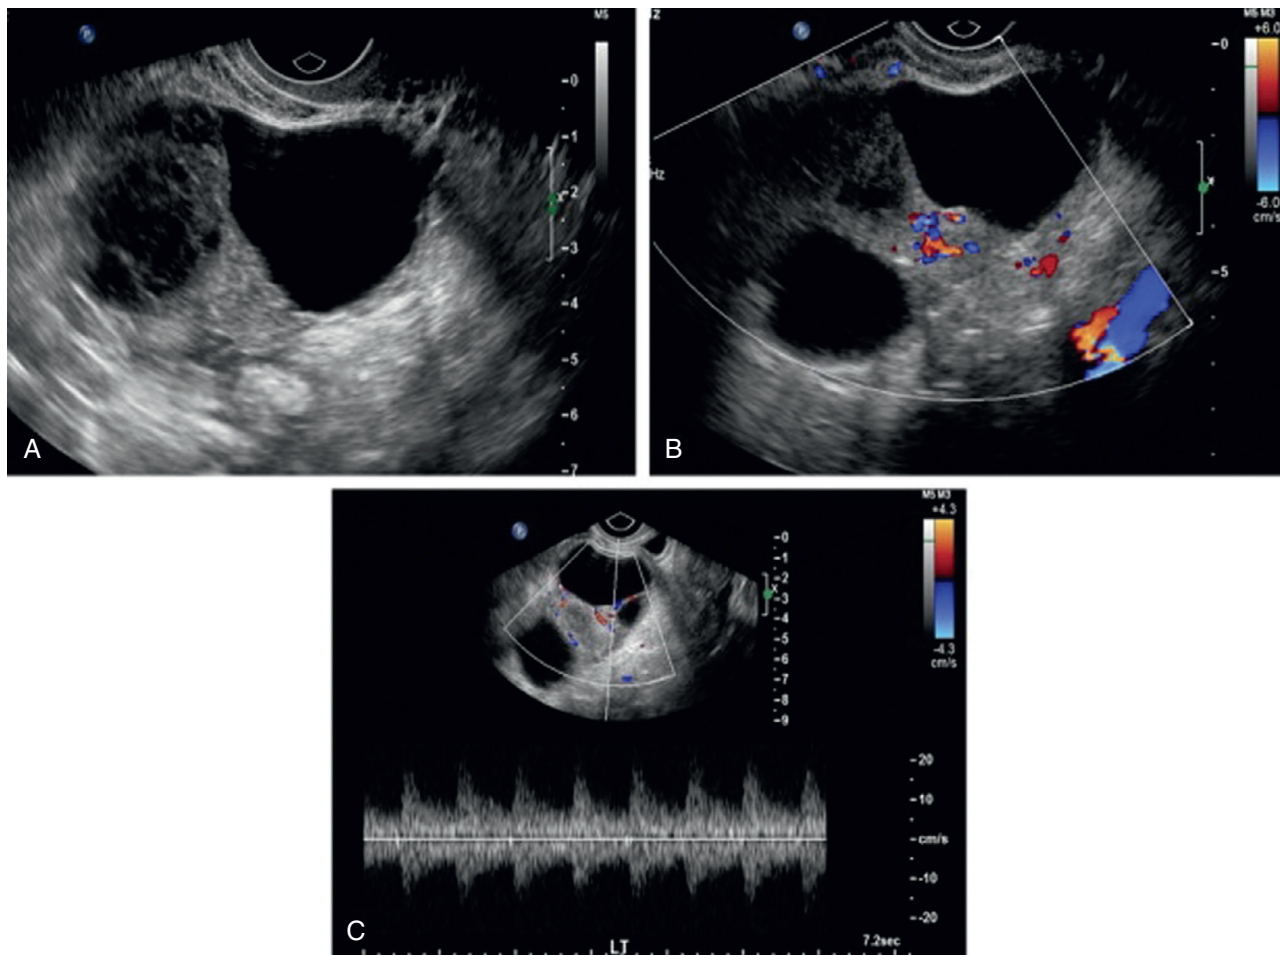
Arterial Doppler signal without venous signal in a patient with surgically proven torsion. The ultrasound examination also demonstrated an associated hemorrhagic cyst. (From Andreotti RF, Shadinger L, Fleischer A: The sonographic diagnosis of ovarian torsion: pearls and pitfalls. *Ultrasound Clin* 2:155, 2007.)
